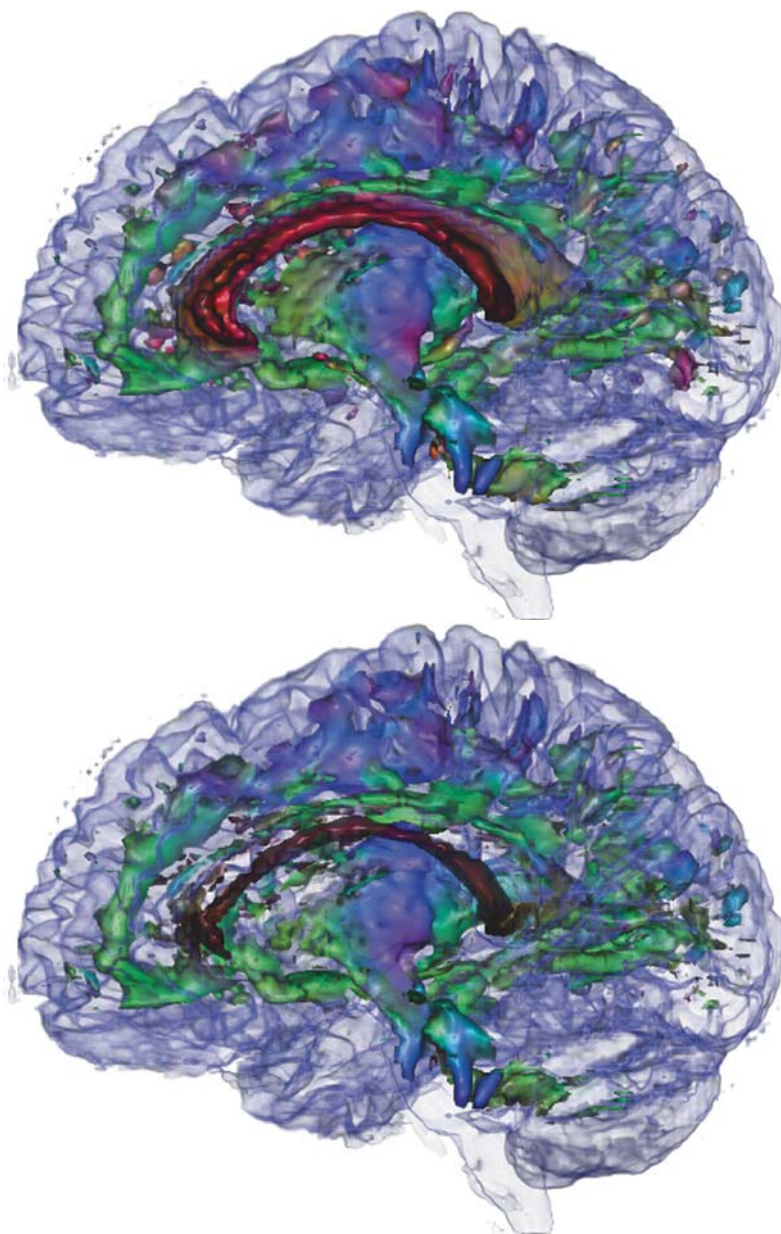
Original image and x-direction (left–right) removed from DTI data to allow to produce a cleaner view of the singuli and the pyramidal tract. The lasting red component is the corpus callosum as seen in the MRI data and is shown here to provide context
